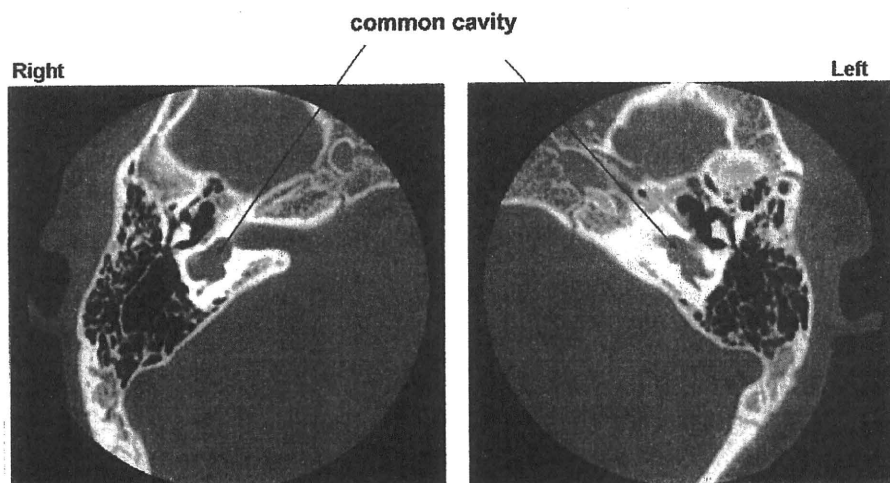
CT scan showing common cavity in case 1.
